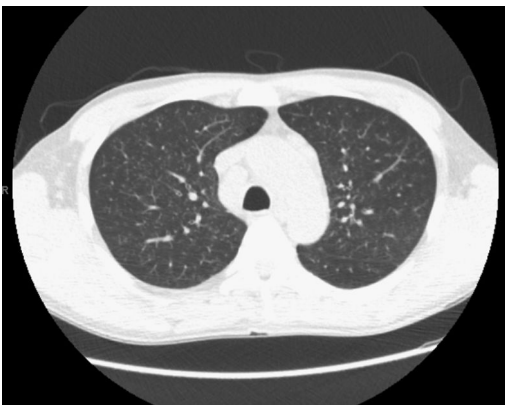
Computed tomography of the chest showing innumerable tiny nodules distributed in a random (miliary) pattern.
